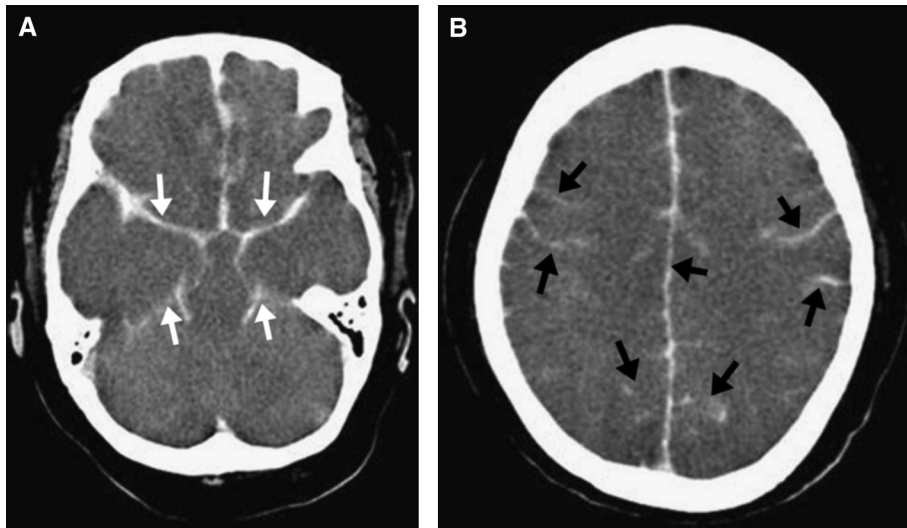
A 47-year-old man with hypoxic ischemic encephalopathy. (A, B) Precontrast computed tomography, showing uncal herniation, increased attenuation over basal cisterns and sylvian fissures, and tentorium (white arrows) and cerebrospinal fluid space (black arrows). Diffuse low attenuation over the bilateral hemisphere with poor grey-white matter differentiation is characteristic for hypoxic ischemic encephalopathy.
